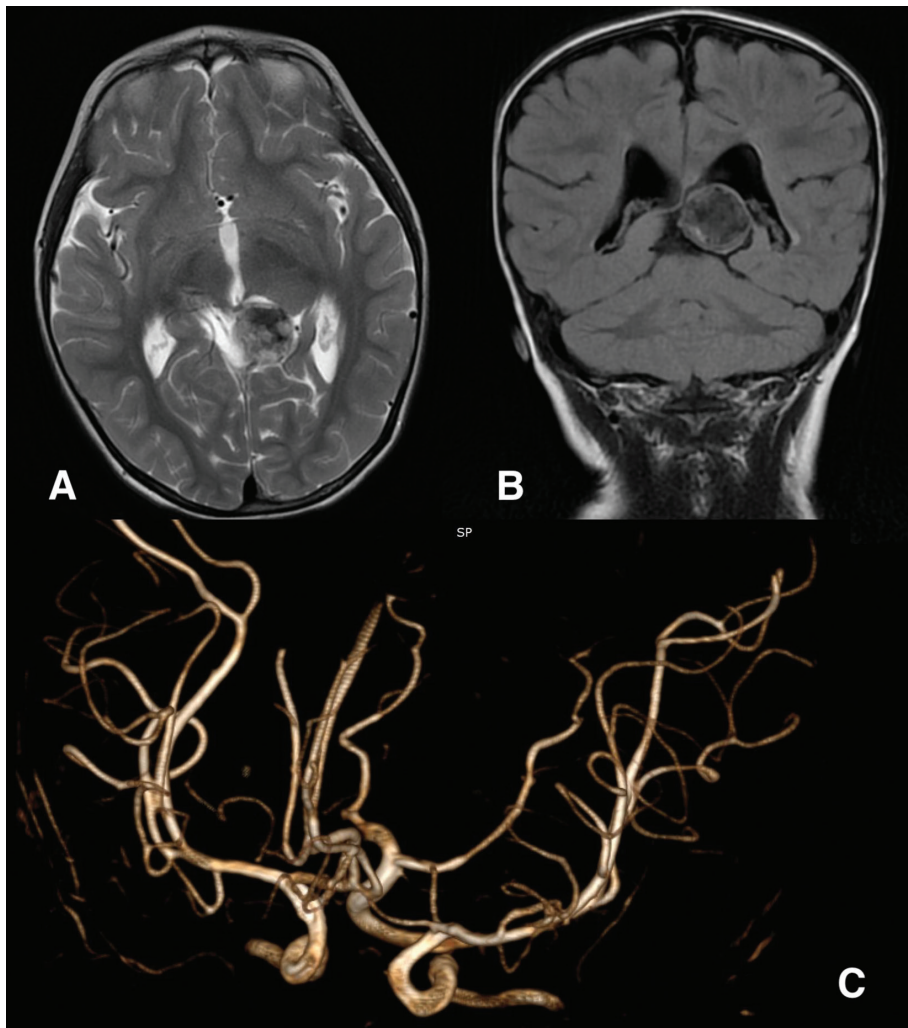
MRI at 3 years. Axial T2 weighted and coronal FLAIR images demonstrate total thrombosis of the malformation, double shrinkage of the varix, no signs of hydrocephalus and damage of the brain parenchyma (A, B). VR reconstruction of the 3D TOF MRI reveals a complete regression and disappearance of the pathological arterio-venous connections (C).
